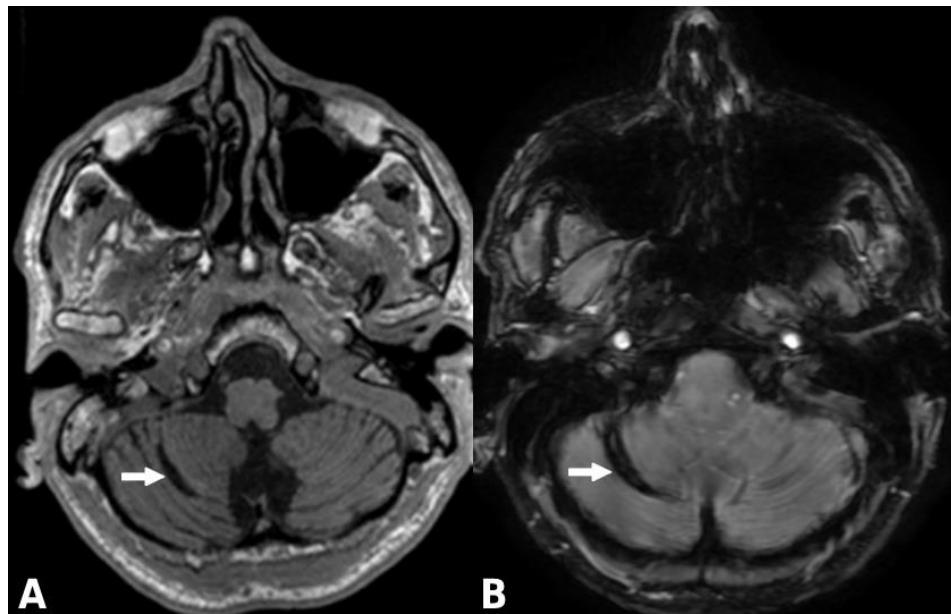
A/ Axial T1 MRI; B/ Susceptibility Weighted Imaging (SWI) MRI showed residual hemosiderin accumulation (arrow).
